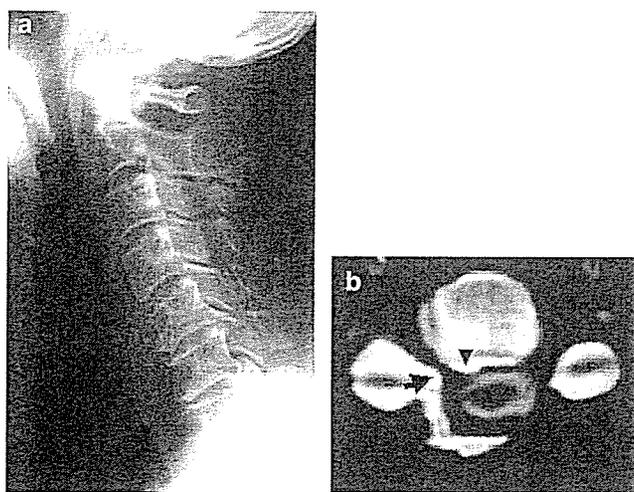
Plain lateral radiogram of the cervical spine and CT findings at C4–C5 level 7 years after first operation in Case 2. (a) Plain lateral radiogram of the cervical spine. (b) CT myelogram of the C4–C5 level. On the plain lateral radiogram, enlargement of the spinal canal, decrease of disc heights at C5–C6 and C6–C7 levels and posterior spur formations at C4–C5 and C5–C6 levels were observed. CT myelogram of the C4–C5 level revealed posterior spur formation (arrowhead) and hypertrophic facet joint (arrow) at the hinge side
